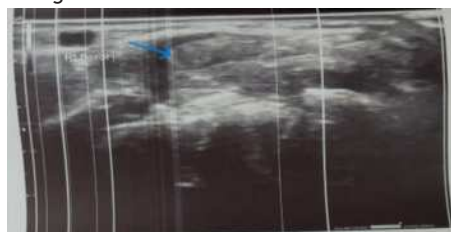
Ultrasound showing tenosynovitis of right forearm flexors (blue arrow)
